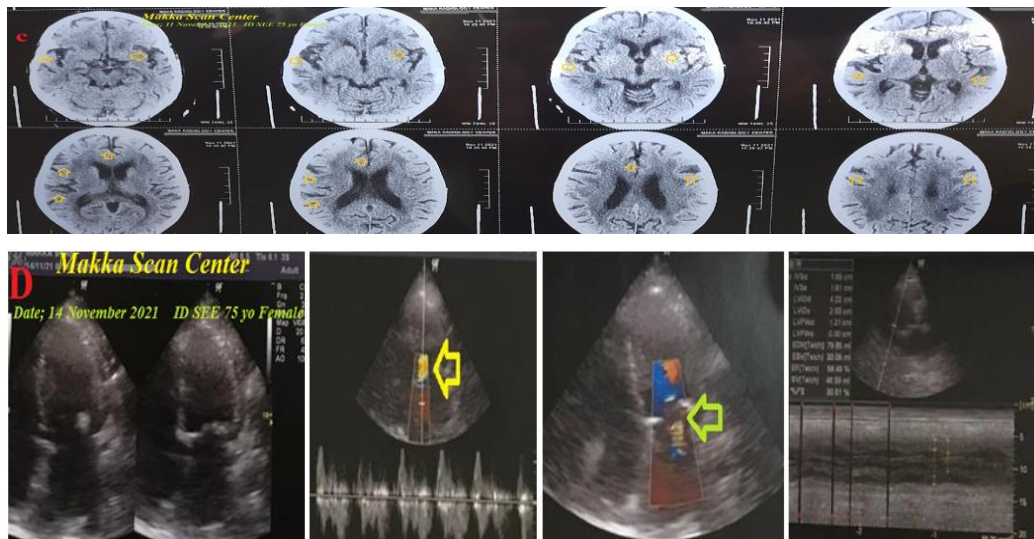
2A-Chest x-ray plain film was done within 3 days before the ICU admission showing flask-shape cardiomegaly, right lung ground-glass opacity (GGO; lime arrows), reversed Halo sign (pink arrows), and bilateral obstruction of costophrenic angle (golden arrows) 2B; Chest CT without contrast was done within 3 days before the ICU admission showing bilateral pleural effusion (golden arrows) with few bilateral small-sized GGO (lime arrows). 2C; Brain CT without contrast was done within 3 days before the ICU admission showing brain involution changes (golden arrows). 2D; Echocardiography with multiple views was done on the day of the presentation showing dilated both left atrium and ventricle, mitral (yellow arrow) and aortic regurgitations (lime arrow), and slight low an EF ratio (56%)
